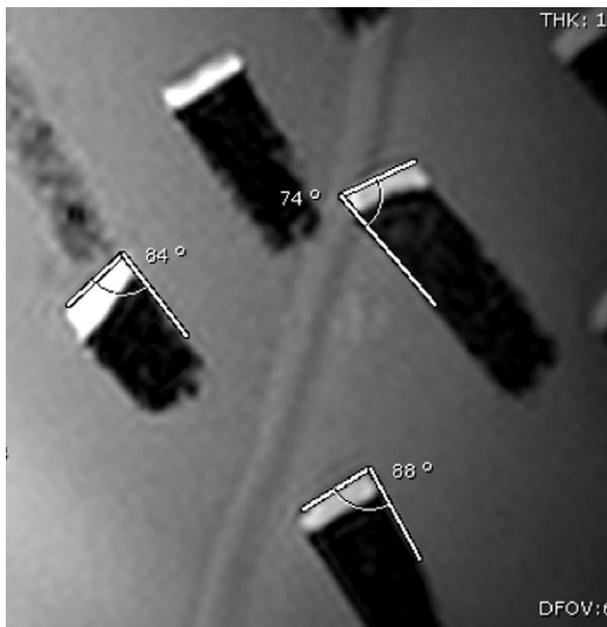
Coronal slices from gradient echo, fluid-sensitive MRI of osteochondral autografts. Perpendicularity of the grafts was measured by use of the intersection of a line drawn parallel to the cartilage cap and a line drawn parallel to the long axis of the osteochondral plug.
